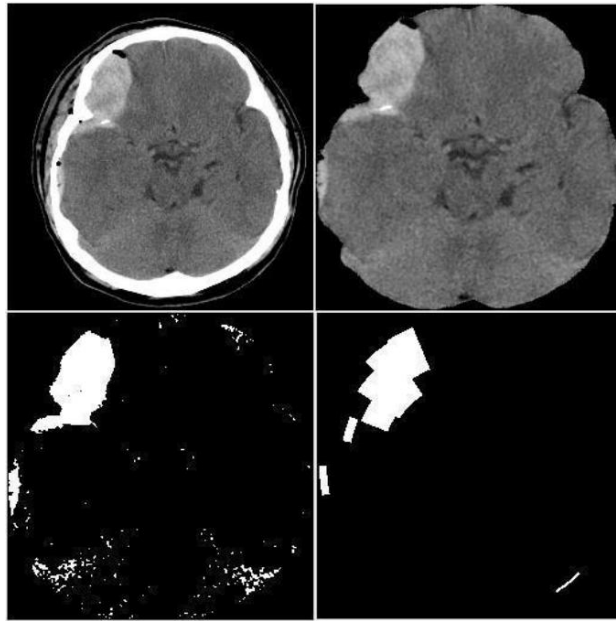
Constructing binary feature vector from TBI CT image: example 2
